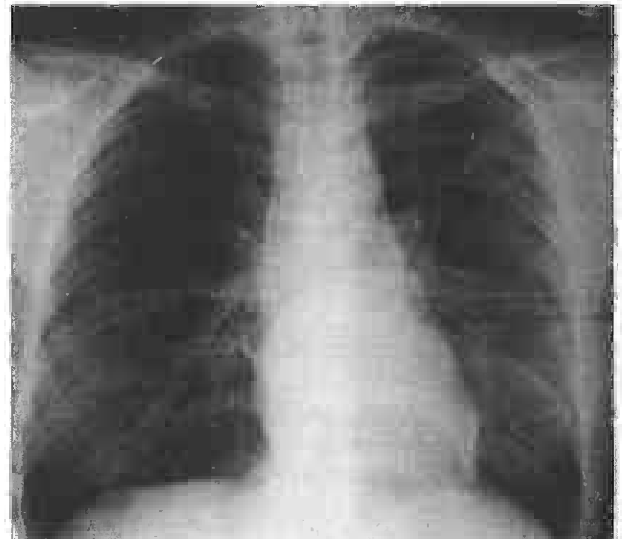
Repeat chest radiograph shows complete resolution of the peripheral air-space opacities after 2 weeks of oral corticosteroid treatment. Residual linear scar is seen in the left upper lobe.
